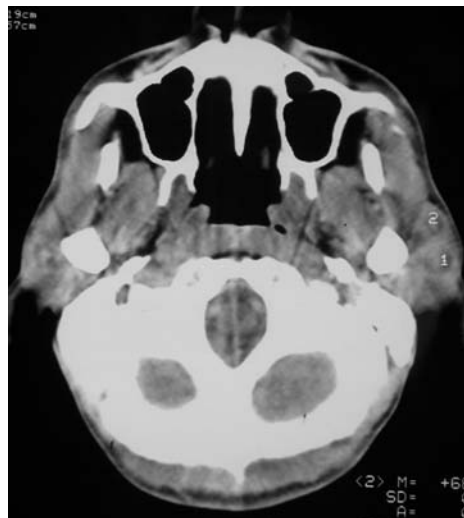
Post contrast Axial CT scan
